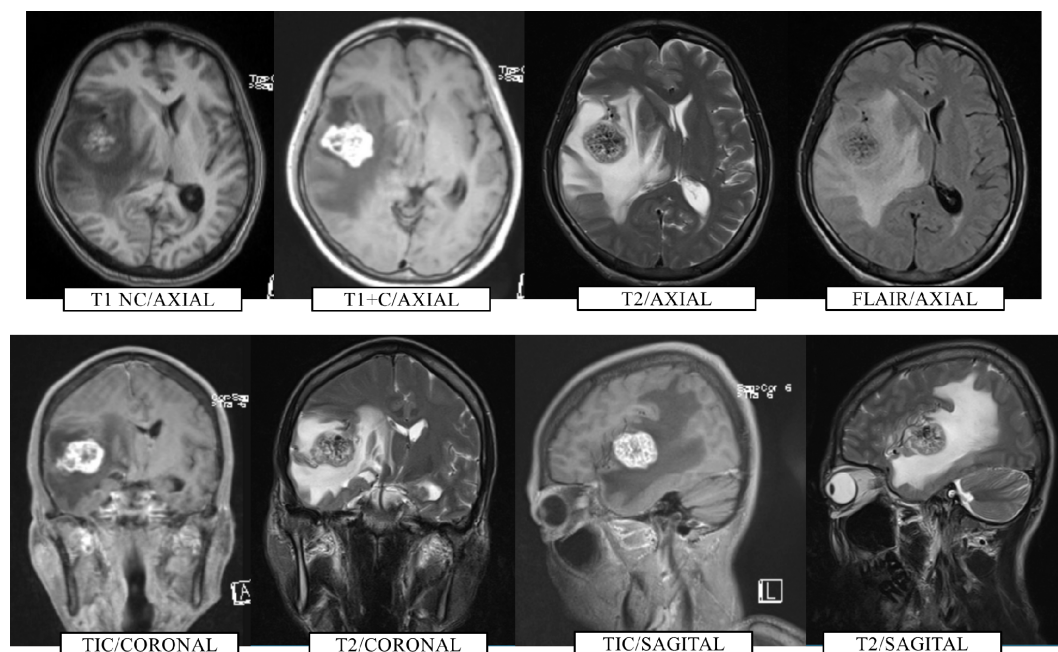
Collaged axial, sagittal, and coronal MRI sections showing a solitary right temporal lobe metastasis with perilesional edema and midline shift.
